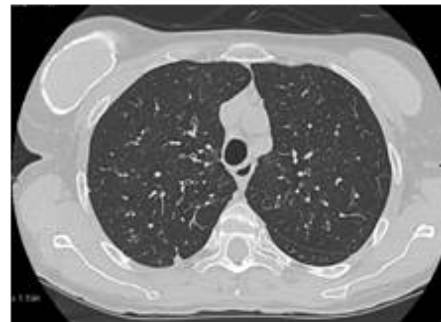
HRCT polmonare.
